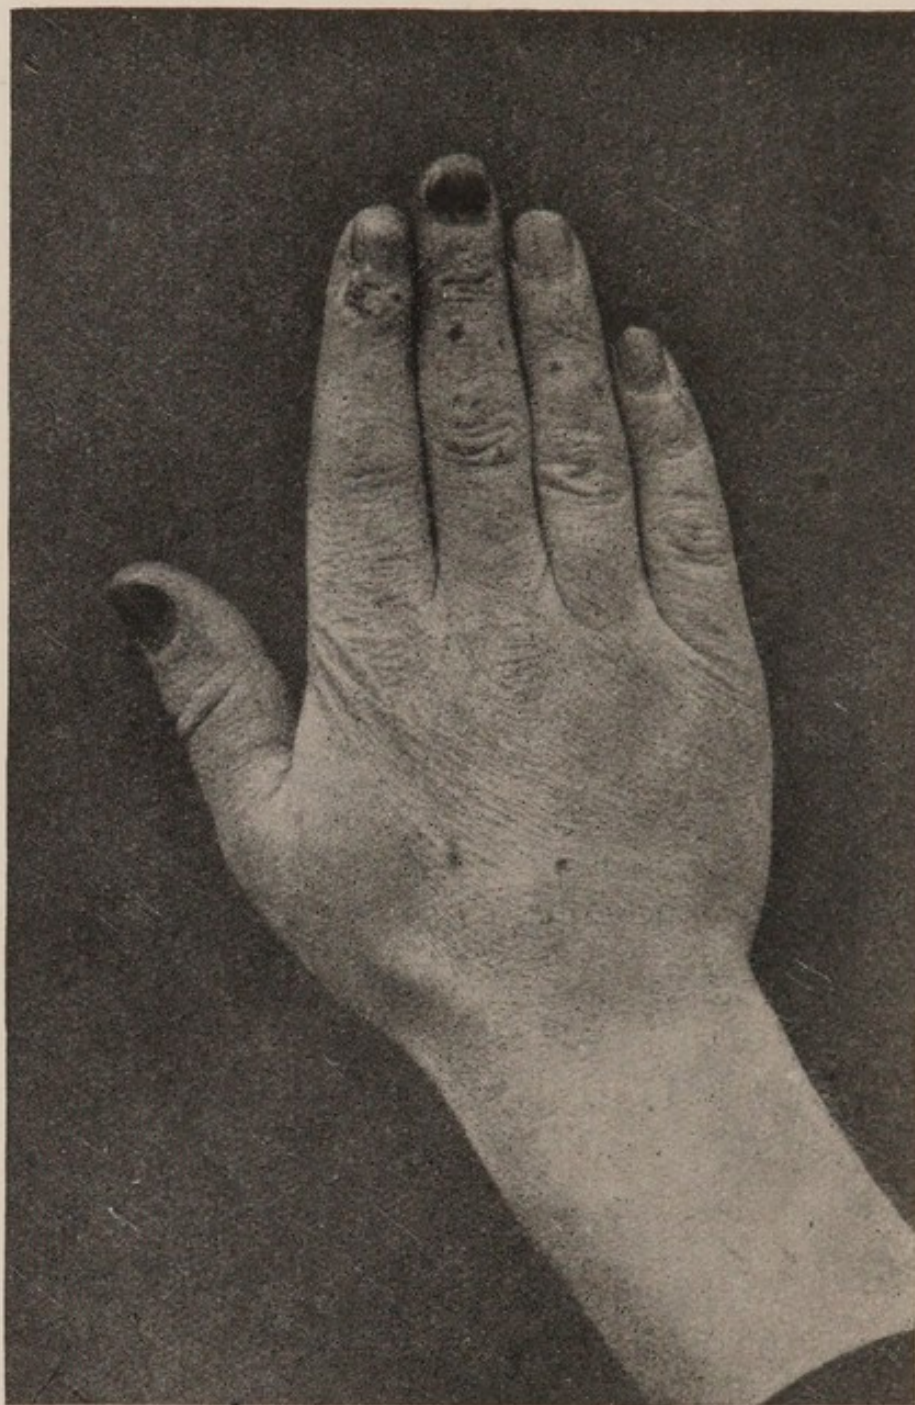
Chronic X-ray burn, showing superficial ulcerations, small warty growths, and changes in the nails.
